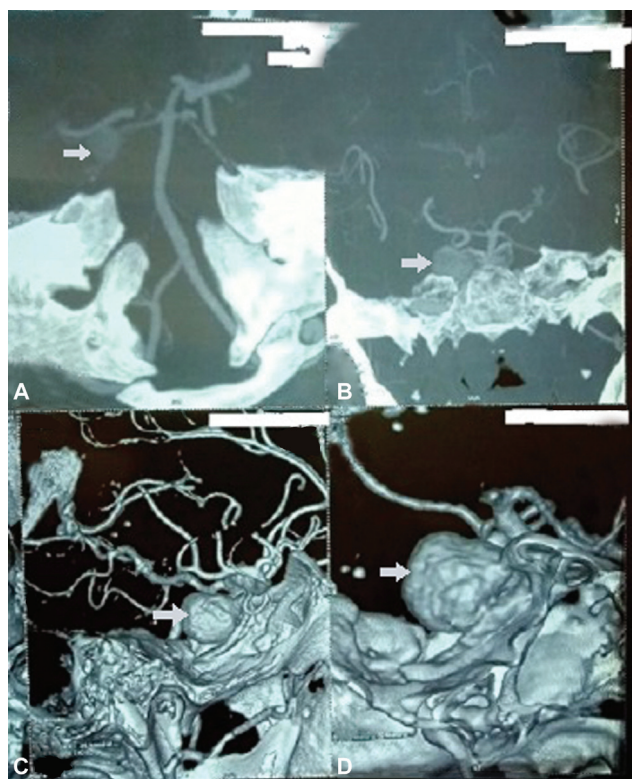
All images showing computed tomographic angiography of the patient with a 16.6×17.3×14.4 mm unruptured lobulated saccular aneurysm (arrows) arising from right distal cavernous internal carotid artery along the dorsal surface causing mass effect. (A) Maximum intensity projection image coronal cut. (B) Maximum intensity projection image axial cut. (C) Volume-rendered image. (D) Volume-rendered image zoomed in.
